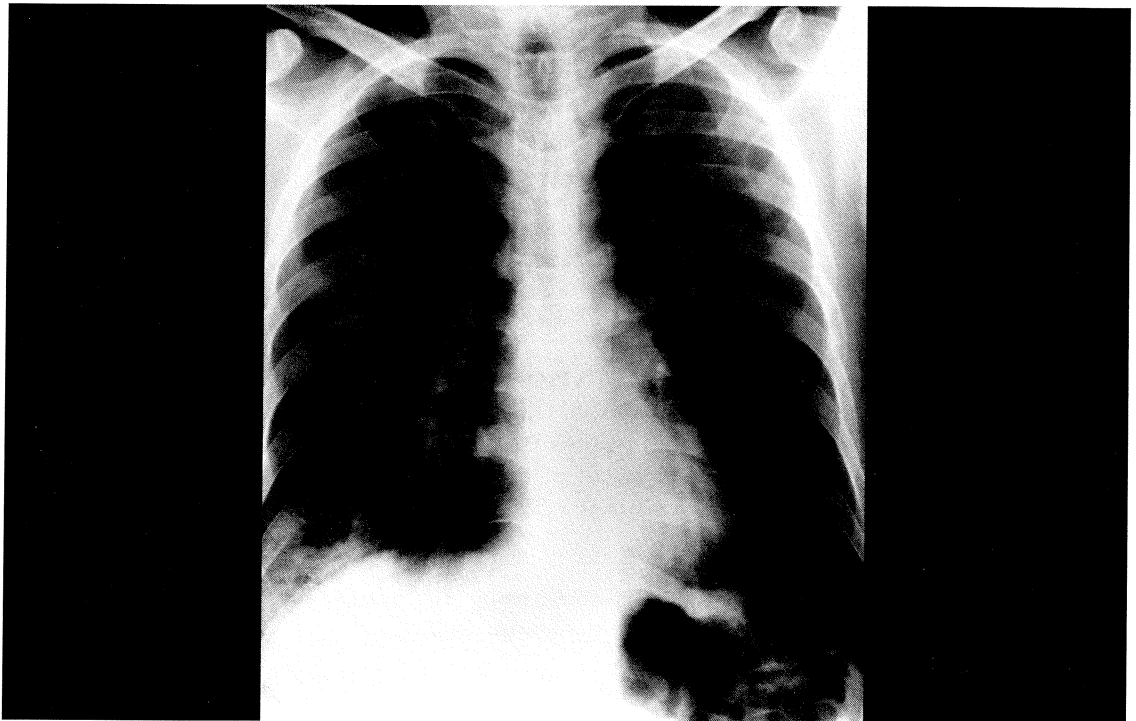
Frontal chest radiograph
